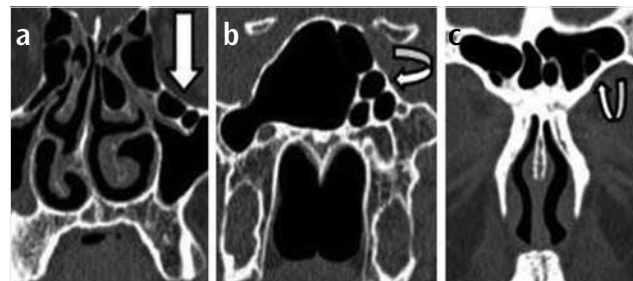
a-c. Coronal CT images of different patients showing: Haller cells (arrow) obstructing the left maxillary sinus ostium (a), Onodi cells (curved arrow) adjacent to the left pterygoid process (b), Supraorbital ethmoid air cell (curved arrow) originating from left orbital plate of frontal bone (c)
